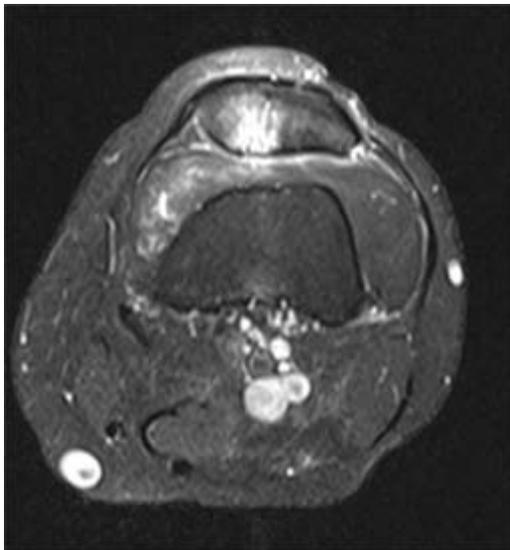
T2-weighted fat suppressed axial MRI.
